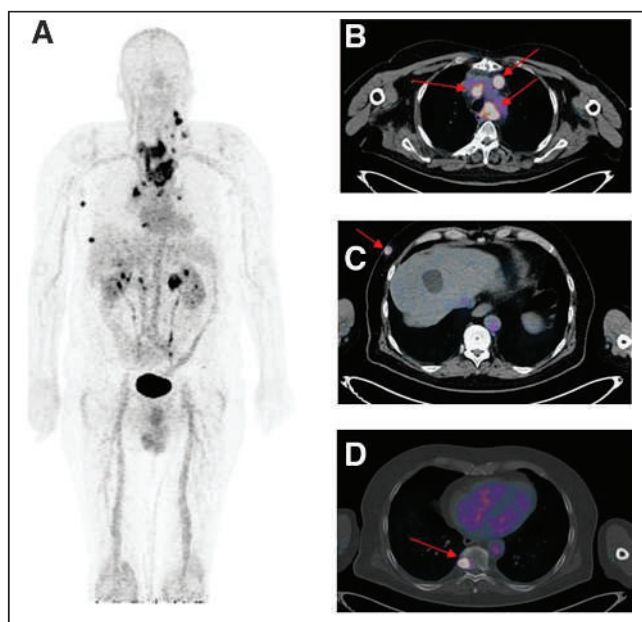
Immuno-PET/CT with anti-CEA BsmAb and ⁶⁶Ga-IMP288 peptide showing pathological lesions with heterogeneous SUV_{max} ranging from 3.0 to 20.1. Maximum-intensity-projection (MIP) image (A) showed several pathological lesions. On the fusion axial images, arrows located mediastinal nodes (B), subcutaneous lesions (C), and bone metastasis (D).
